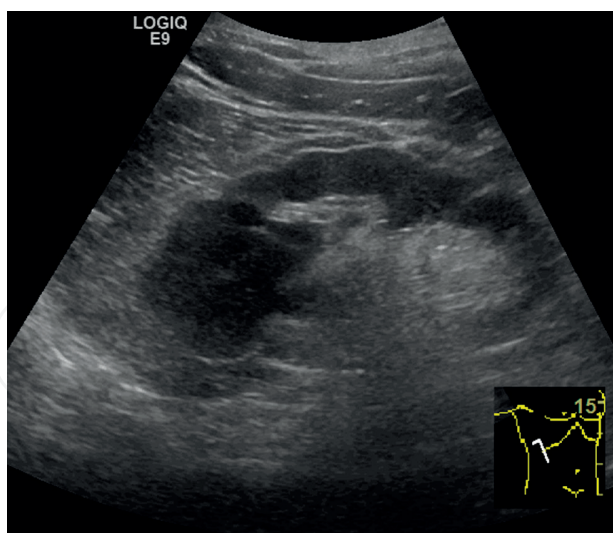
Renal cell carcinoma. Gray scale ultrasonography of the right kidney. At the upper pole, there is a hypoechoic tumor, relatively well defined.
